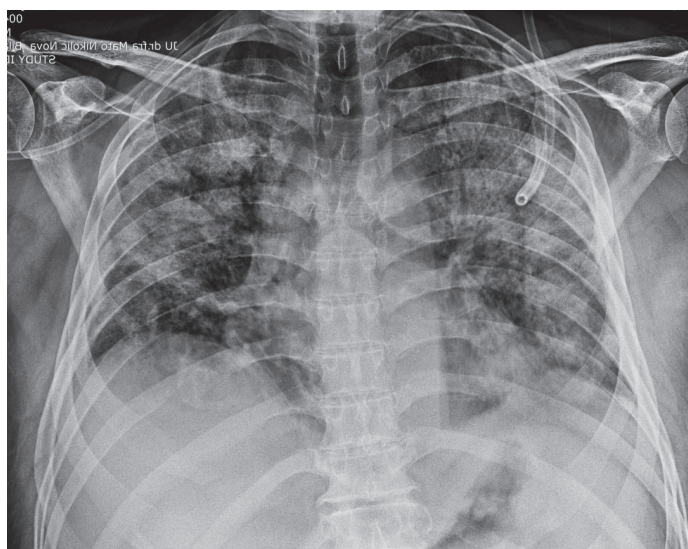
Radiograph of the chest organs after the transfer of the patient (Source: Author)
